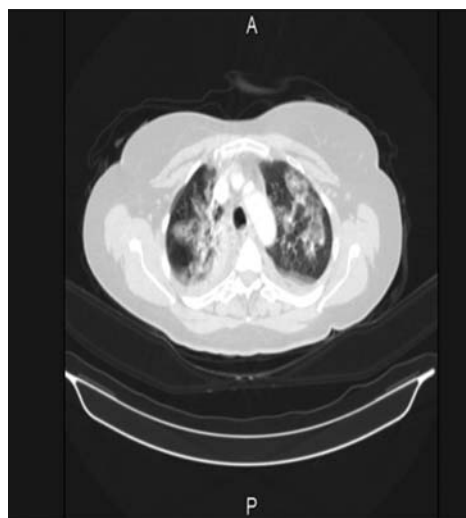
CT of patient's lungs
